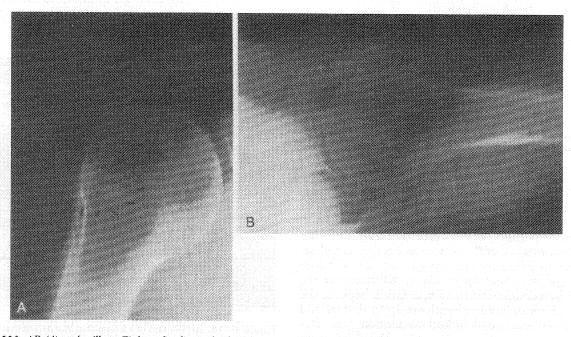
AP (A), and axillary (B), lateral radiographs demonstrating calcific tendonitis near the subscapularis insertion on the lesser tuberosity. (From Re P, Karzel RP: Management of rotator cuff calcifications. Orthop Clin North Am 24:128, 1993.)
